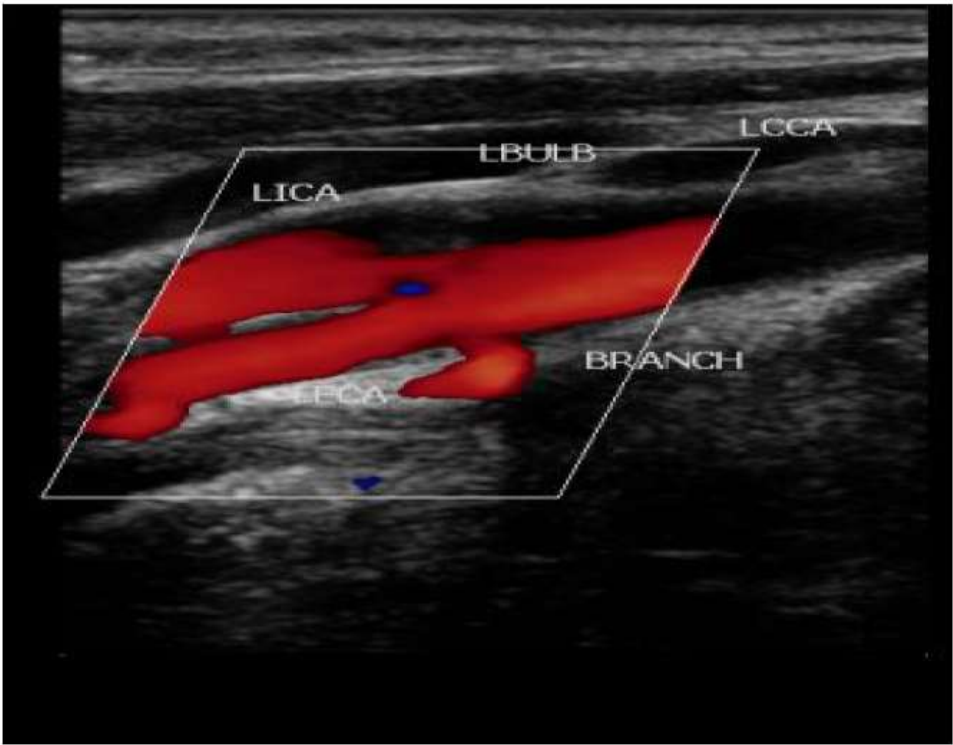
Left carotid bifurcation, longitudinal section, colour-coded Doppler mode.
